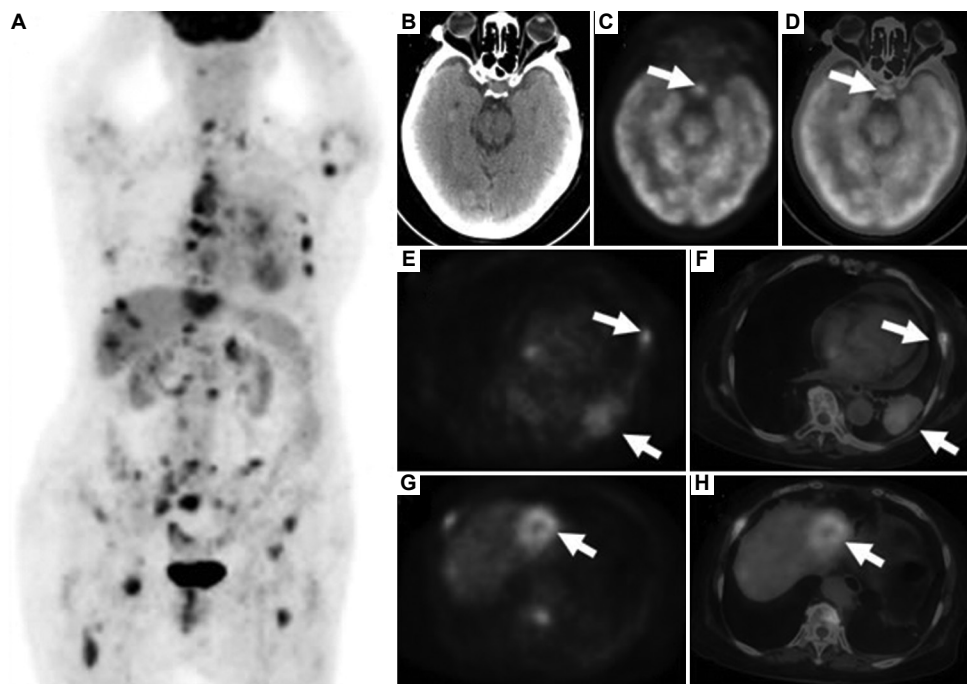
Whole-body ^{18}F -FDG PET/CT images of a patient with lung cancer and multiple systemic metastases demonstrating pituitary hypermetabolism. (A) MIP PET image shows multiple hypermetabolic lesions. (B-D) Brain CT, PET, and fused PET/CT images, respectively, reveal increased FDG uptake in the pituitary gland (white arrows), with an SUV_{max} of 7.3. (E and F) Cross-sectional PET and fused PET/CT images of the chest, respectively, demonstrate a hypermetabolic mass in the left lower lobe of the lung with adjacent rib destruction (white arrows). (G and H) Abdominal PET and fused PET/CT images show a hypermetabolic lesion in the left hepatic lobe suggestive of liver metastasis (white arrows). This figure is adapted from Ju *et al.*,⁵ available under a Creative Commons Attribution (CC BY 3.0) license.
